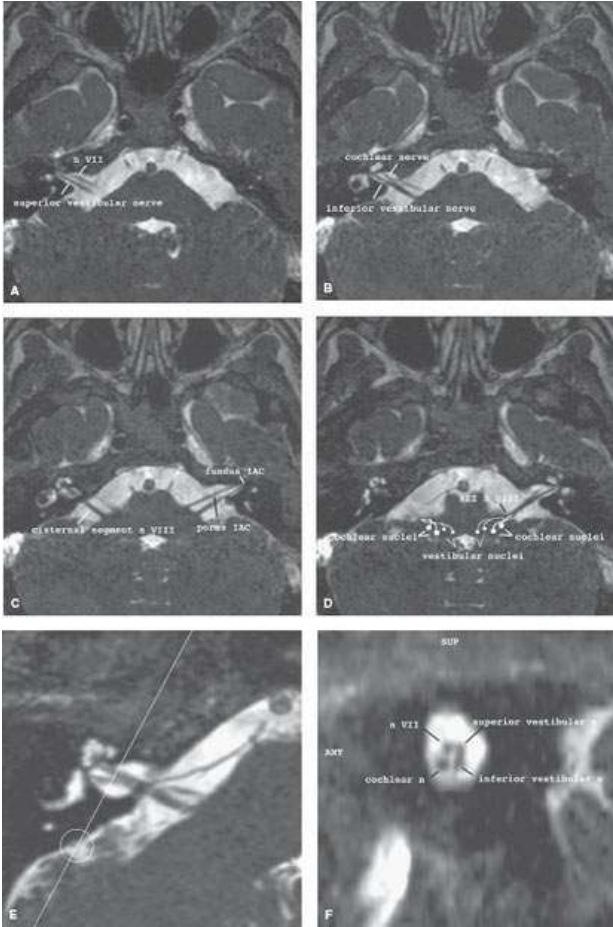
Normal magnetic resonance imaging anatomy of the internal auditory canal. On axial heavy T2-weighted images (CISS), the course of cranial nerves VII and VIII can be discerned. A–D: Oblique reformatted images (E, F) show the relation between the four nerves within the internal auditory canal.
